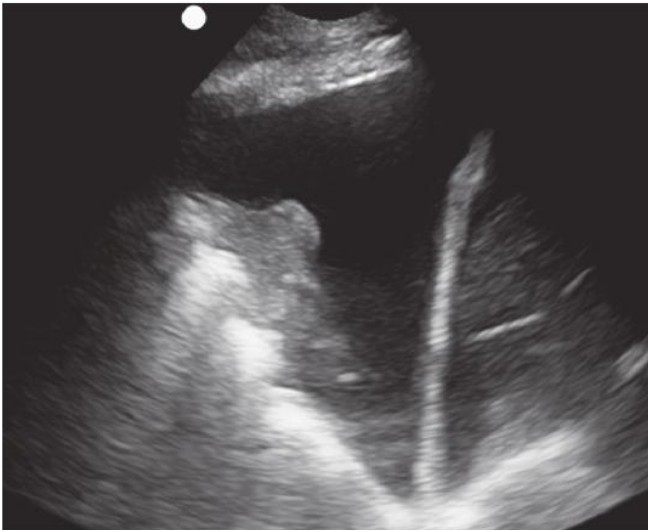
Pleural effusion. [Reproduced with permission from Silva FR, Mills L: Chapter 7. Pulmonary, in Ma OJ, Mateer JR, Reardon RF, et al (eds): *Ma and Mateer's Emergency Ultrasound*, 3rd ed. New York: McGraw-Hill Education; 2014. Fig. 7-4, Part D, p. 177.]
